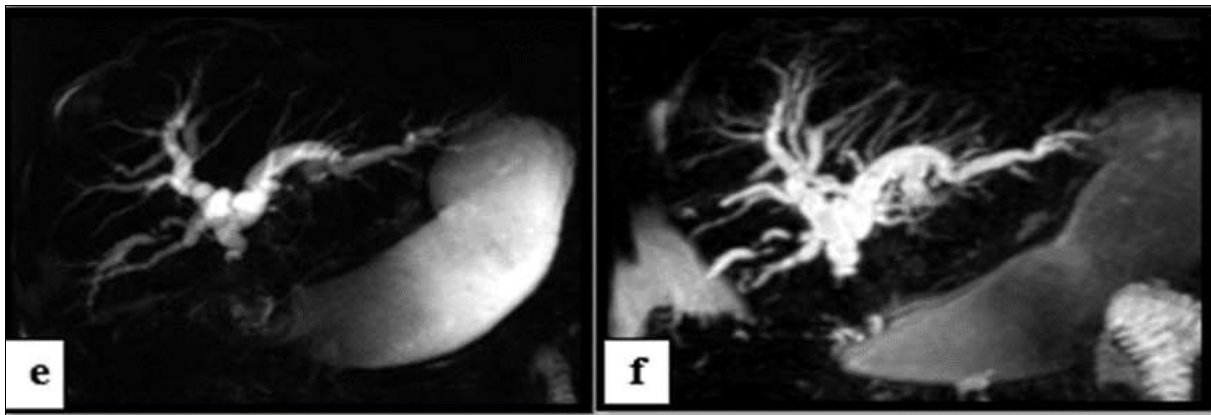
Female patient aged 68 years old with history of duodenal carcinoma presented with progressive jaundice. Coronal T2 weighted MR image (a), Axial T2 weighted MR image (b), Axial T2WI-STIR (c) & Axial T2WI-zoom (d) show large ill-defined irregular shaped mass is seen infiltrating GB bed, related liver parenchyma, gastric pylorus and duodenum (proximal to duodenal papilla) measuring about (7.5x6.5cm) in its maximum dimension and displays intermediate T2 signal (thick arrow) & faintly high STIR signal (thin arrow). There is also few small discrete hepatic focal lesions (thin arrow) and multiple small peritoneal soft tissue nodules (dashed arrow) likely metastasis. Coronal oblique 2D MRCP (e) & Coronal oblique 3D MIP-MRCP (f) show moderate dilatation of intrahepatic bile ducts, CHD and proximal CBD which shows abrupt bile signal termination. Mid and distal portion of CBD are not visualized and Pancreatic duct is not dilated
